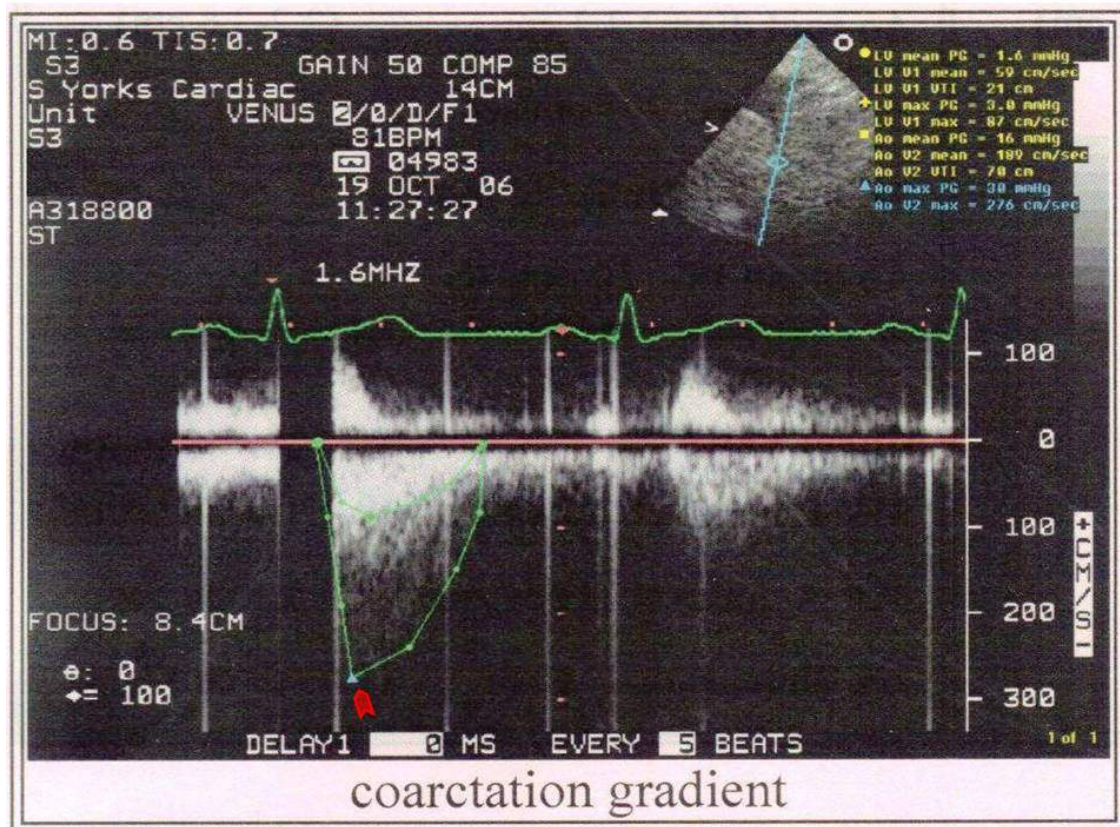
Transthoracic Doppler echocardiogram showing aortic coarctation with a diastolic tail. A coarctation gradient of 30-40mmHg was seen (arrowhead) while the average aortic pressure was 16mmHg. The peak velocity in aorta was 276cm/sec.
